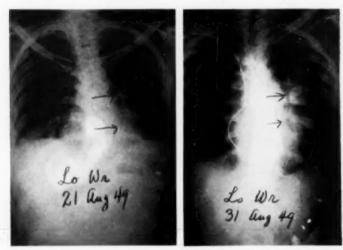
Case 10: X-ray film of the chest with and without radio-opaque material injected through a catheter with the tip in the right ventricle revealed obvious opacification of the shadow in the left hilum.
